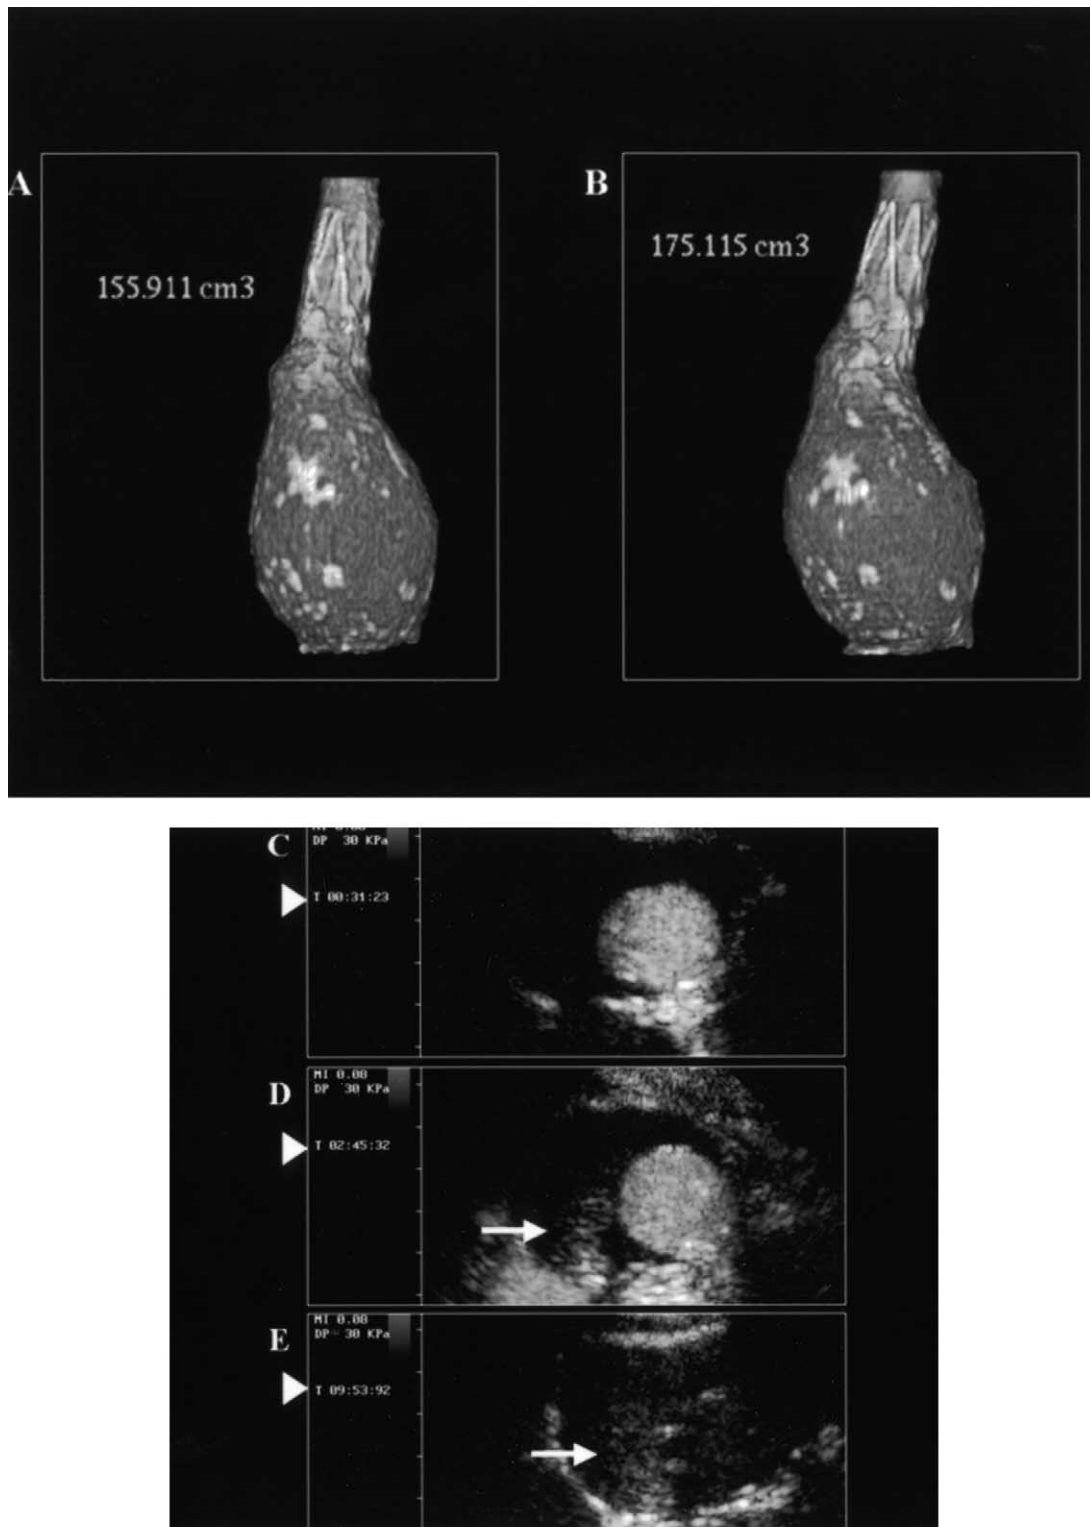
Patient 14, 52-year-old man with hypodynamic endoleak. Compared to the 1-month CT control (A), the 12-month follow-up AAA volume shows a significant increase (B). However, no endoleak could be demonstrated at CTA. CUS shows the absence of enhancement in the first minute scan after contrast material injection (C); a posterior enhancement is appreciated more than 2 minutes after injection of contrast material (D, *arrow*), persisting for almost 10 minutes (E, *arrow*). *Arrowheads* indicate the time (minutes and seconds) after injection of contrast material. At the *top left corner*, main parameters of CUS are indicated: mechanical index (MI) and derated pressure (DP).
